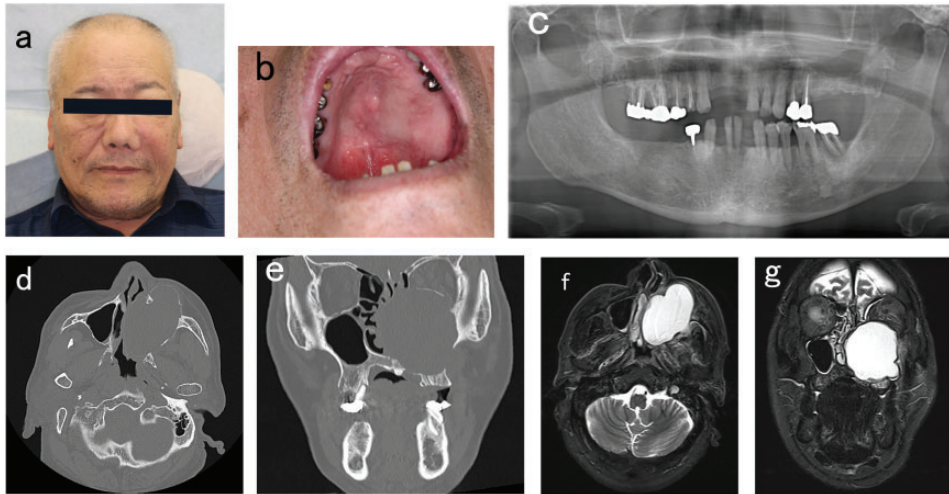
(a, b) Facial and intraoral photographs. (c) An orthopantomogram showing the left maxillary sinus floor extended downward. There was no destruction of the left maxillary alveolar bone. (d) Axial and (e) coronal views of computed tomography showed the lesion extending from the left maxilla into the maxillary sinus and further into the nasal cavity and orbit. Visibly, the content of the lesion is a liquid of uniform concentration. (f) Axial and (g) coronal views of magnetic resonance imaging showed intrinsic T2-weighted high signal intensity in the lesion extending from the left maxilla into the maxillary sinus and further into the nasal cavity and orbit. Visibly, the content of the lesion is a liquid of uniform concentration.
